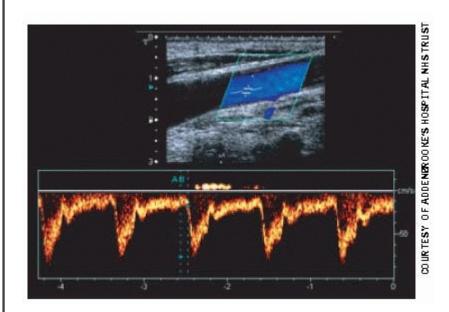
A normal Duplex US of the right common carotid artery. It can measure the flow rate in the artery (here 76cm/s). The Doppler trace (orange) is displayed below the main image.
